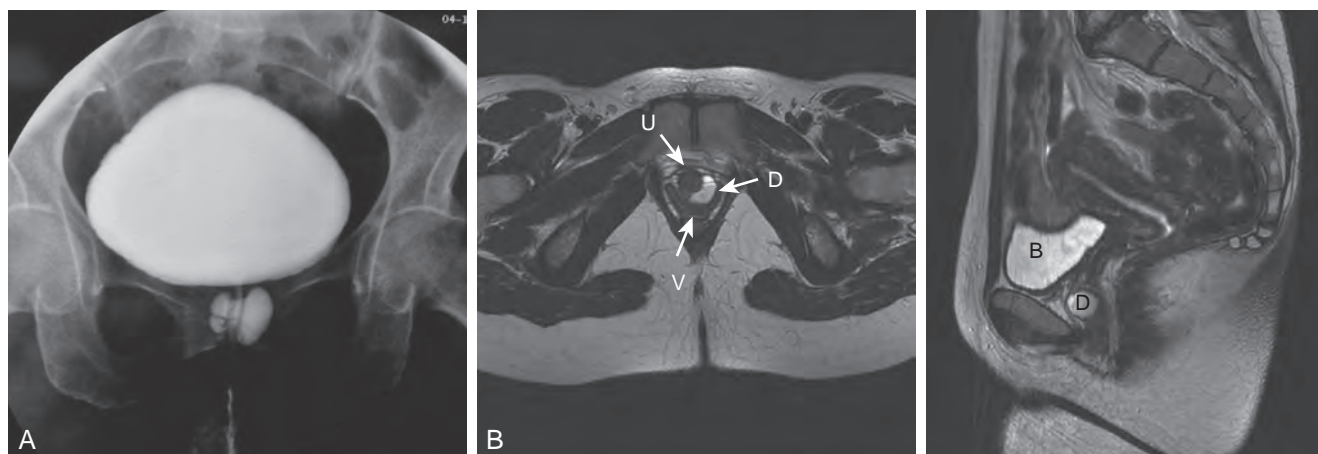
Imaging of urethral diverticula. A, Anterior-posterior view from a voiding cystourethrogram demonstrating a collection of contrast below the bladder, suggesting a urethral diverticulum. B, Surface coil magnetic resonance image with both sagittal (left) and axial (right) T2 images demonstrating the relevant anatomy of a patient with a urethral diverticulum (D). B, bladder; U, urethra; V, vagina.
